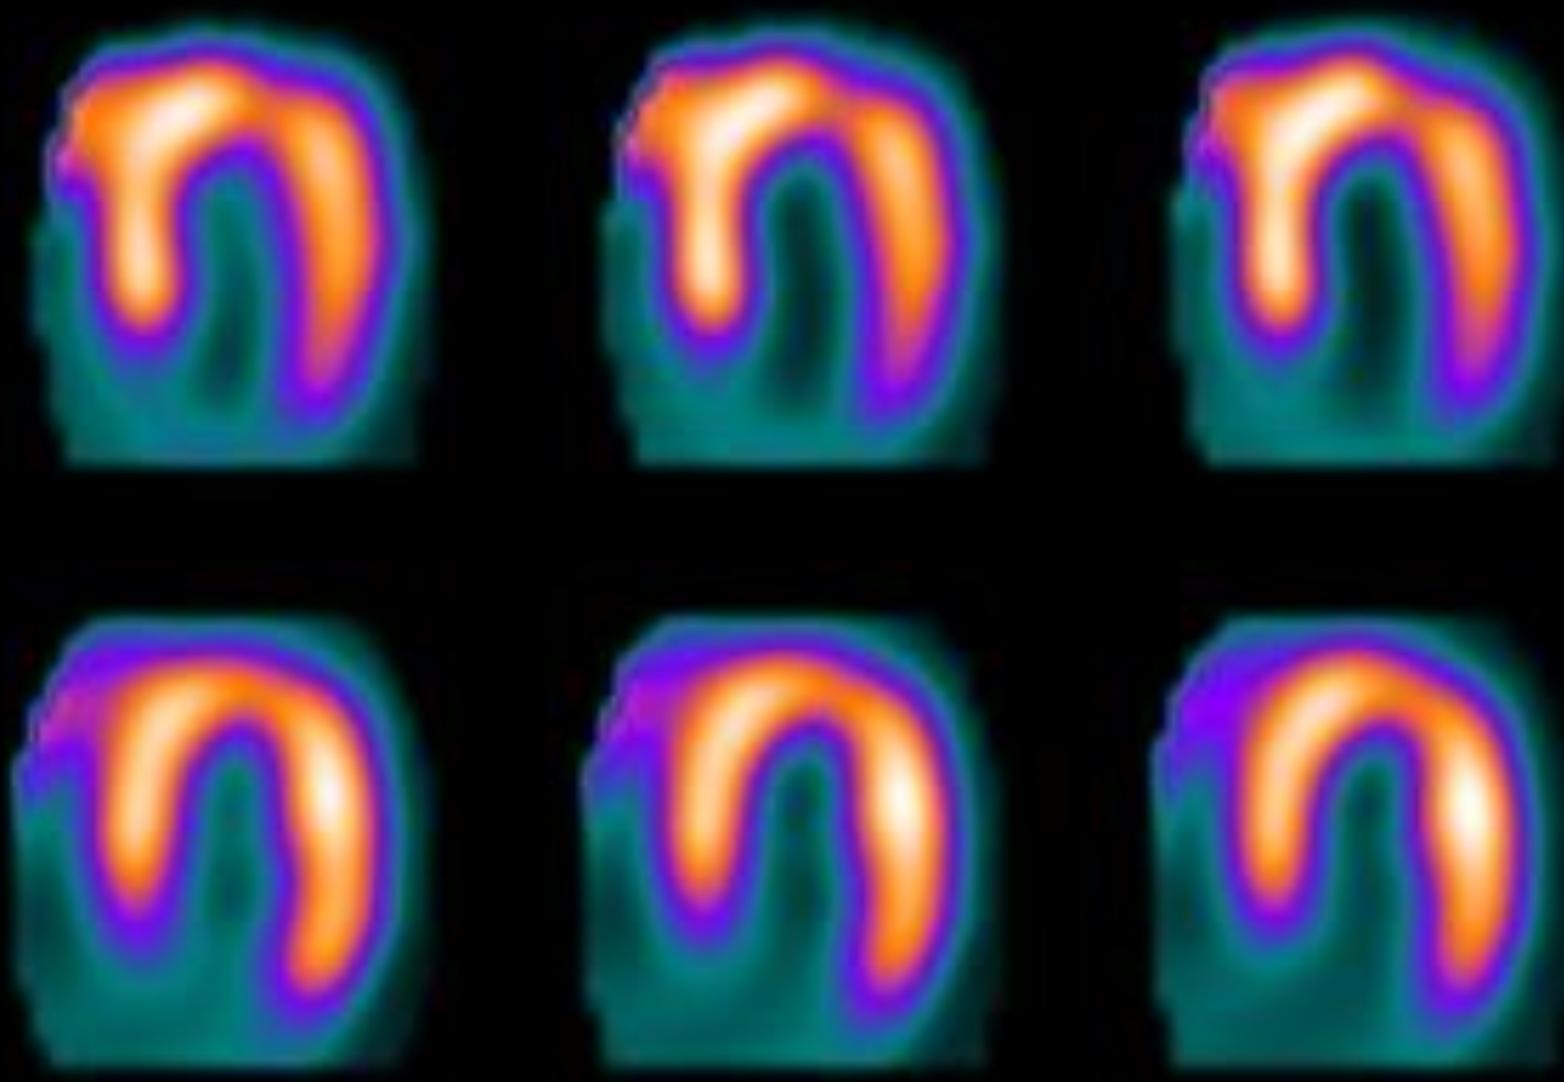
IMAGENS CORRIGIDAS PELA CT E IMAGENS NÃO CORRIGIDAS PELA CT
